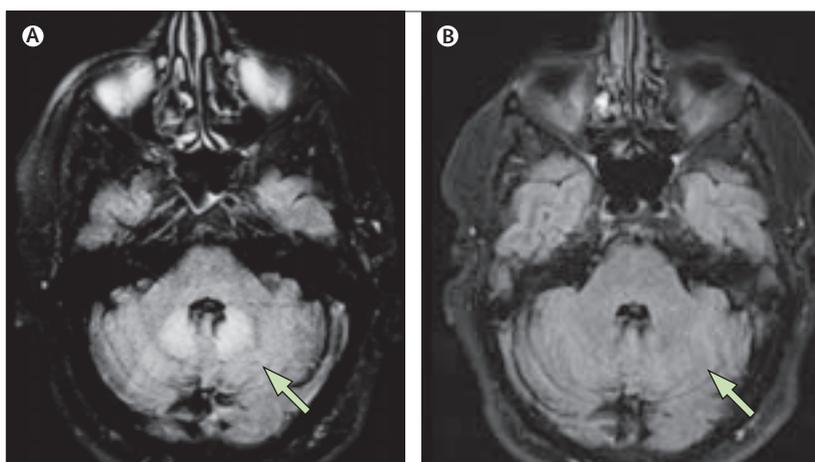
MRI of brain in May, 2010 (A) compared to follow up in July, 2010 (B) Showing symmetric swelling and increased signal intensity of (A) the cerebellar dentate nuclei (arrow), and (B) complete resolution of signal changes in the dentate nuclei (arrow).
